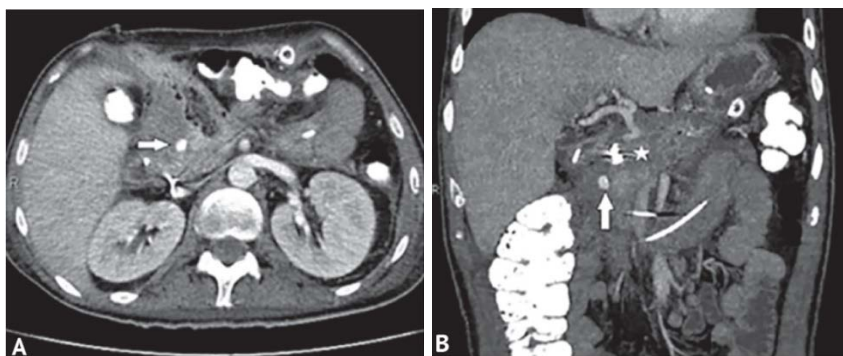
Computed tomography of the abdominal cavity with contrast enhancement. A - axial projection; B - front view. An aneurysm of the gastroduodenal artery system with a diameter of 10 mm is preserved (arrows in Figs. 8A, 8B). Spiral emboli in the lumen of the gastroduodenal artery (asterisk in Fig. 8B)
